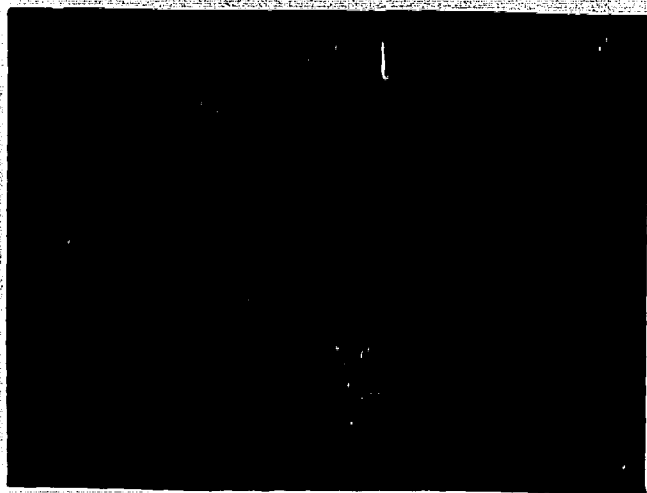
"Normal" pseudo-x-ray stimulus.
